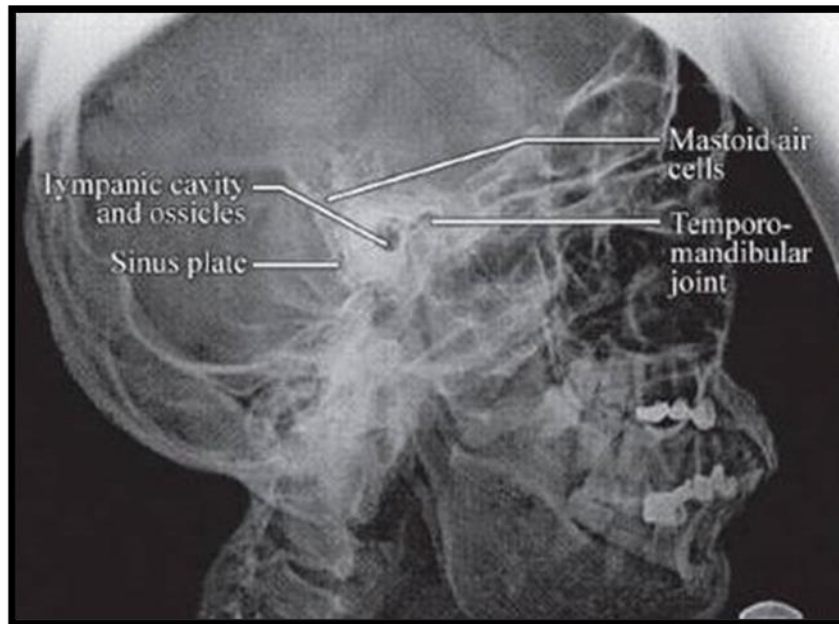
Figure showing left side mastoid x-ray in Schuller's view¹²
